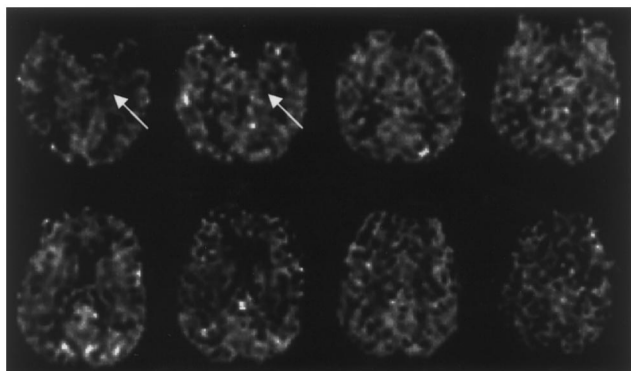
CASL perfusion MRI in a patient with left temporal lobe epilepsy, showing subtle hypoperfusion in left mesial temporal structures (arrows). Images are in radiological orientation.
